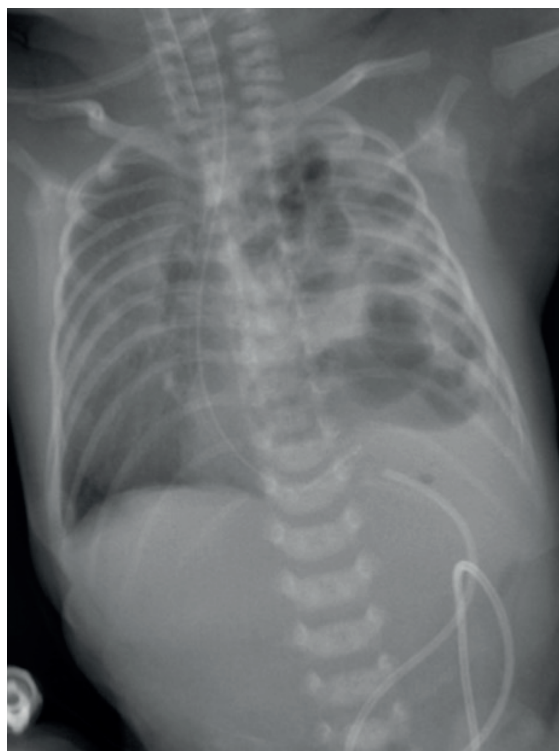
The first radiographic imaging of the patient. The loops of the intestine are found in the left hemithorax, with the mediastinum shifted to the right. The umbilical catheter trace is displaced to the left due to the shifting of the abdominal organs. The abdominal cavity contains very little gas.
